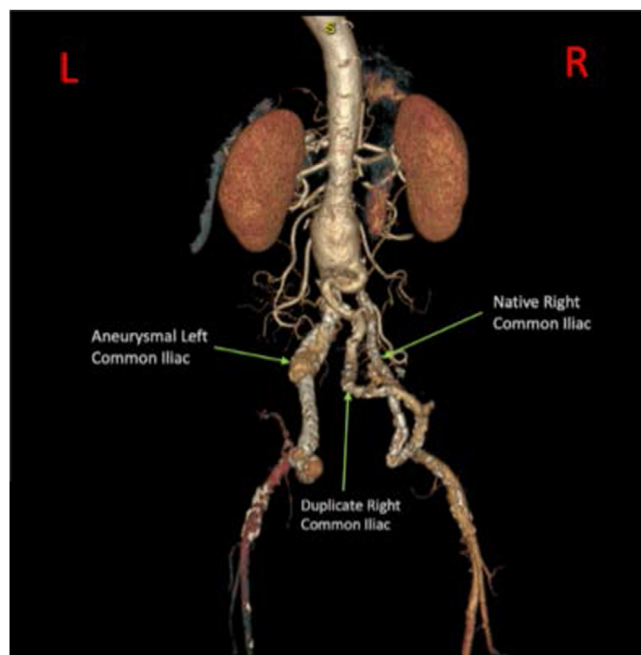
Preoperative CTA showing abnormal iliac artery anatomy, posteroanterior view.
